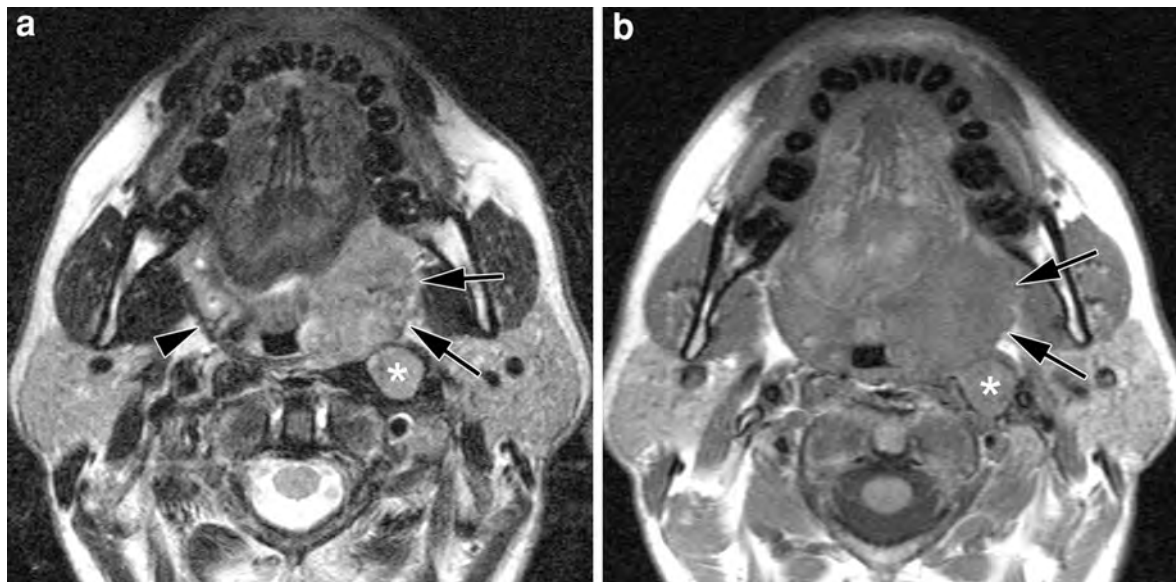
Axial T2-weighted (a) and plain T1-weighted spin echo image (b) in a patient with a *left-sided* tonsillar cancer. The soft tissue mass involves the palatine tonsil, grows through the pharyngeal constrictor muscle into the parapharyngeal space
